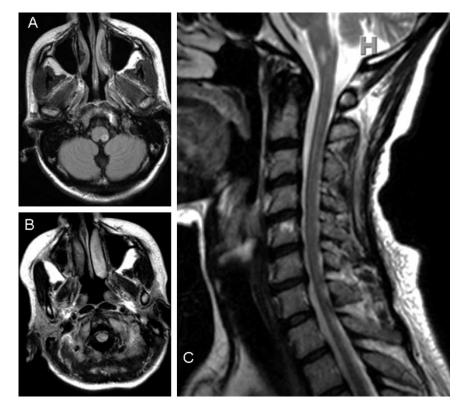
Brain and cervical spine MRI. (A) Initial axial fluid attenuated inversion recovery (FLAIR) sequence showing high signal intensity in the left dorsolateral medulla with minimal central cystic gliosis. (B) Axial FLAIR sequence showing high-intensity lesion on the left aspect of the upper cervical spinal cord. (C) Sagittal T2-weighted sequence showing high-signal-intensity lesions in anterior proximal spinal cord and medulla oblongata.
